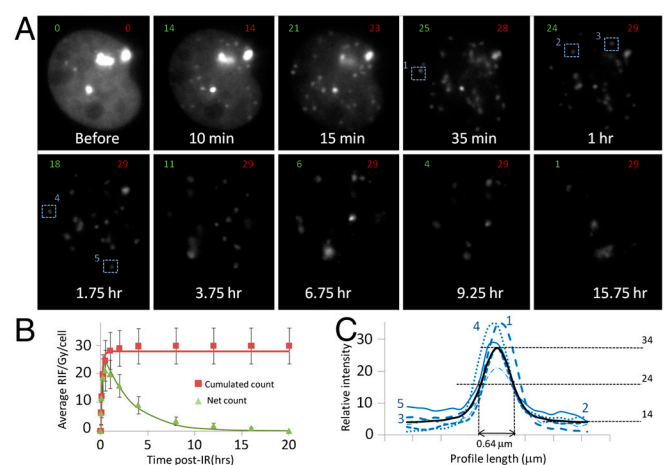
Time-lapse imaging of MCF10A transiently transfected with 53BP1-GFP after exposure to 1 Gy of X-rays. (A) representative snapshots of best focal plane for a 3D time lapse. (B) RIF counts from 21 different time lapses (three independent experiments) leads to an average for $T_{1/2, \text{induction}} = 6.5$ min, $T_{1/2, \text{resolution}} = 2.1$ h, $\alpha = 28$ RIF/Gy. $R^2 = 0.99$ and t test P value = 0.003 for the fit. (C) One-dimensional intensity profiles of five different regions of interest indicated by blue dash box in A.
